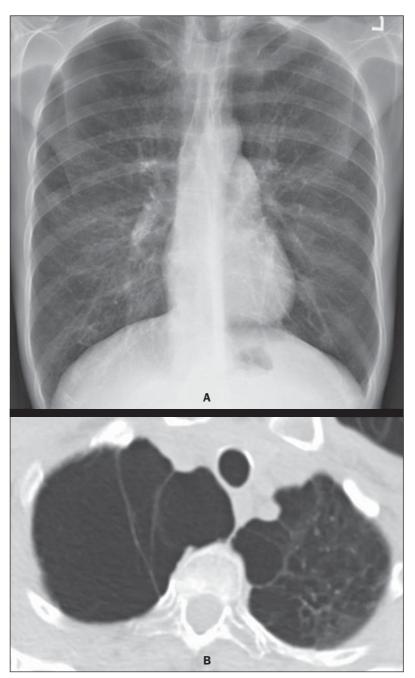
A: Posteroanterior chest radiographic image. B: Computed tomography – pulmonary parenchyma window. Section at the level of the upper lung lobes.
